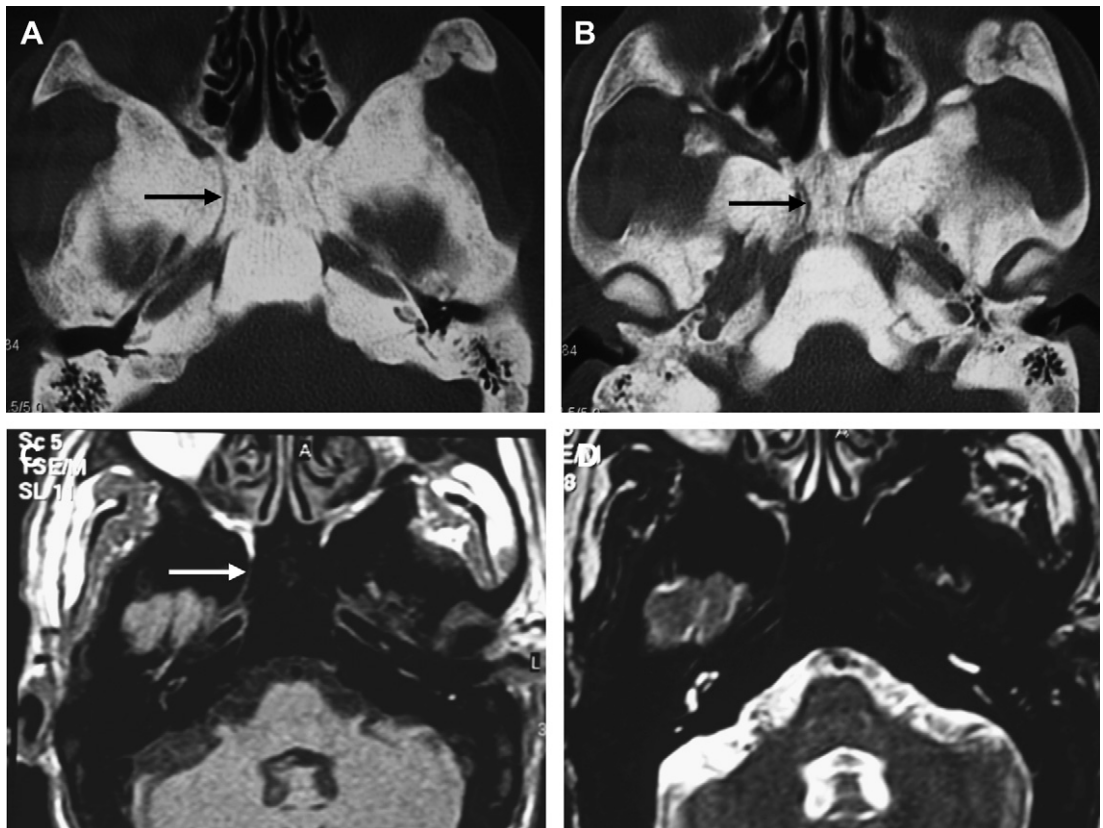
(A, B) Axial CT images on a bone algorithm show diffuse skull base osteosclerosis with obliteration of the normal trabecular pattern by dense, amorphous, and structureless bone. Note the involvement of the temporal bone including the otic capsule. Axial T1-weighted (C) and T2-weighted (D) images show extensive signal void of the entire skull base reflecting the replacement of the bone marrow by dense compact bone. There is slight bone expansion leading to stenosis of the neurovascular foramina of the skull base. Note the stenotic foramen rotundum compressing V2 (black arrows in A and C) and the vidian canal (white arrow in B).
